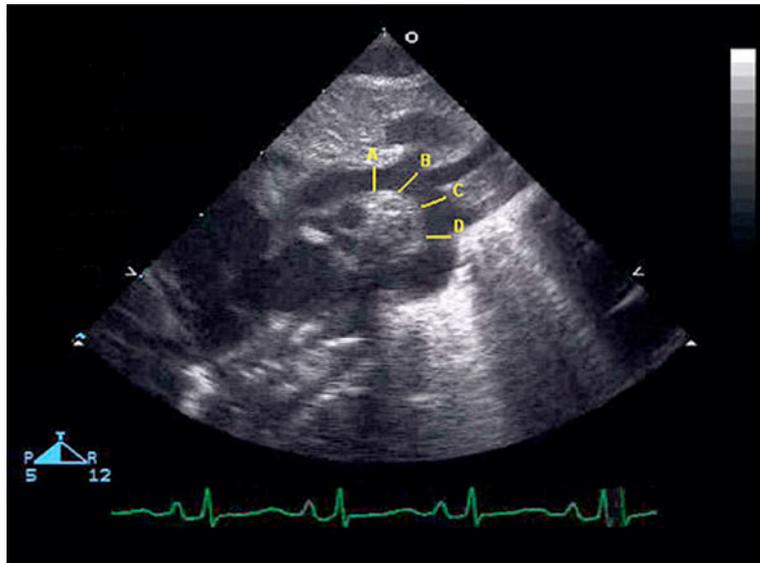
Aortic arch measurements. This high parasternal view shows measurements of the ascending aorta (*A*), proximal transverse aortic arch (*B*), distal transverse aortic arch (*C*), and aortic isthmus (*D*)
